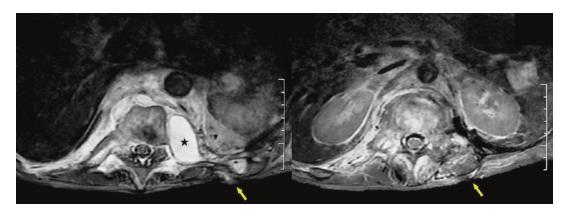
Spinal paraspinal TB abscess (*star*) with superficial cutaneous fistula (*arrows*). Spinal axial MRI on T2-weighted images
